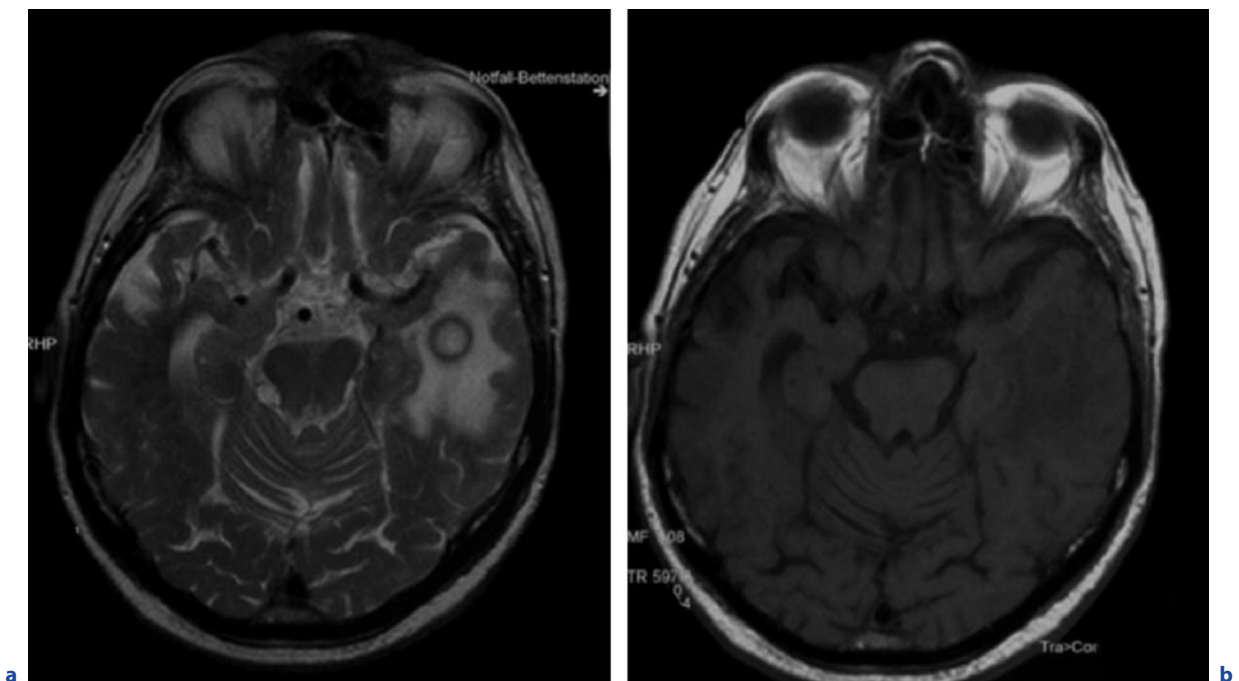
Mature abscess, late capsule stage. An 80-year-old man, immunosuppressed because of colitis ulcerosa. a Axial T2-weighted image. b Axial T1-weighted image before contrast administration. c–g see next pages
